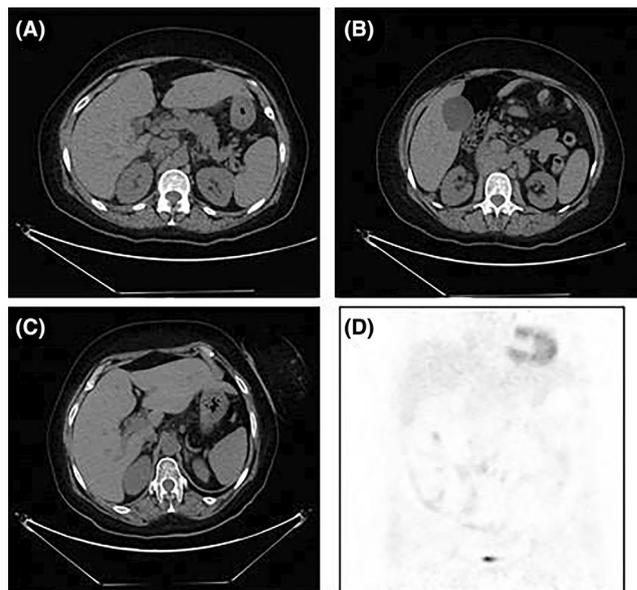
CT-scan at relapse post allo-SCT. (A) Enlarged lymphadenopathies localized near the hepatic hilum (major axis 36 mm). (B) Several retroperitoneal lymphadenomegalies. (C) Regression of abdominal lymphadenopathy by CT scan at day +90 after the infusion of brexu-cel. (D) Complete metabolic remission by PET on day +90 after brexu-cel infusion (no high fluorodeoxyglucose uptake).
